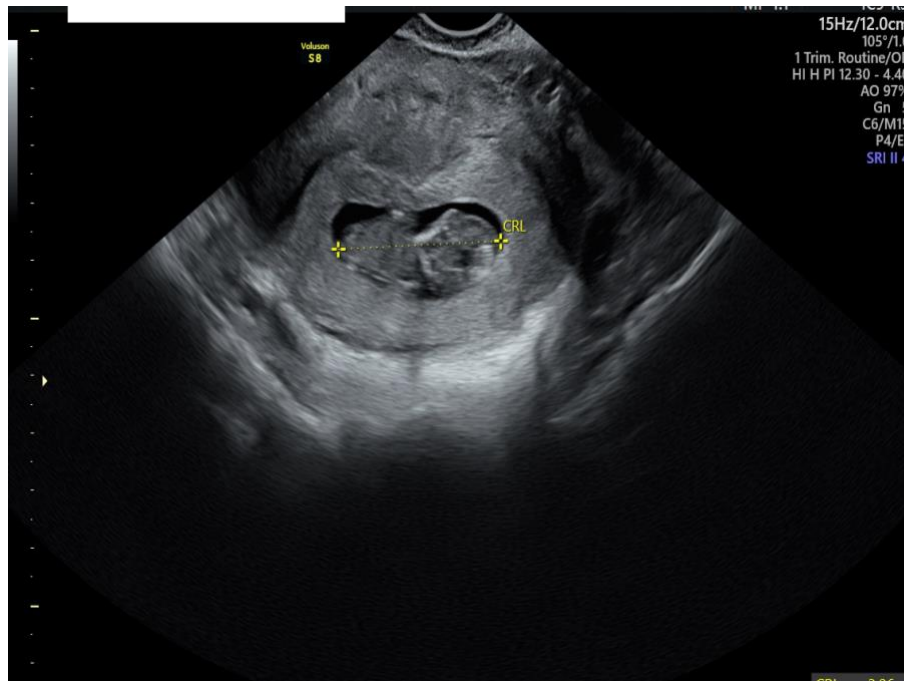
Follow-up transvaginal ultrasound at 10+1 weeks of gestation demonstrating CRL measurement and a relatively small gestational sac, with reduced GS–CRL difference
